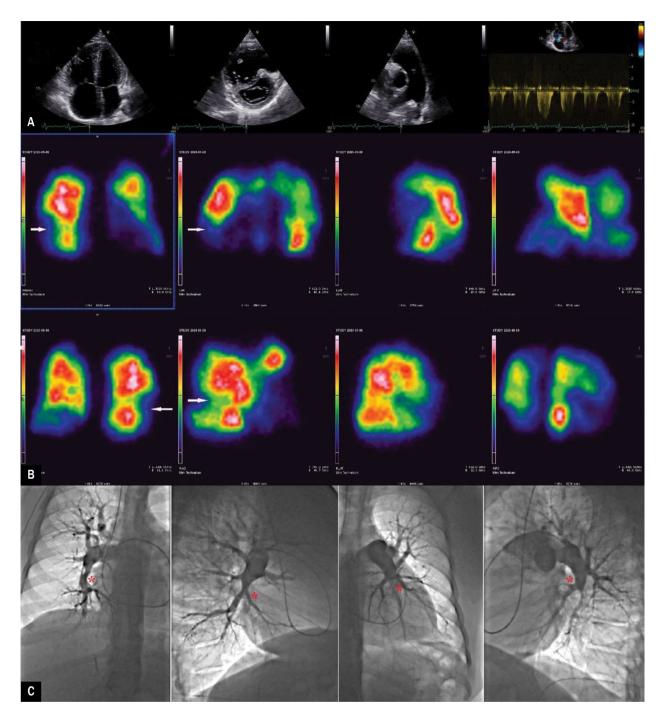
Echocardiography shows the enlargement of the right heart chambers and pulmonary trunk: right ventricle (RVID) 53 mm, right atrial area 28 cm², RV:LV ratio 1.4. D-shaped left ventricle in systole, secondary to interventricular septum flattening, indicates the right ventricular pressure overload. Severe tricuspid regurgitation is shown with the peak velocity of 4.8 m/s; B. Lung scintigraphy shows numerous segmental and subsegmental perfusion deficits in both lungs (white arrows); C. Pulmonary angiography reveals the widening of main branches of the pulmonary artery, organized clots located in the distal parts of both lower lobes branches (red asterisks) and multiple webs lesions at segmental levels. From the left: right pulmonary artery (posteroanterior and right anterior-posterior oblique 90 views) and left pulmonary artery (posteroanterior and left anterior-posterior 90 oblique views)
